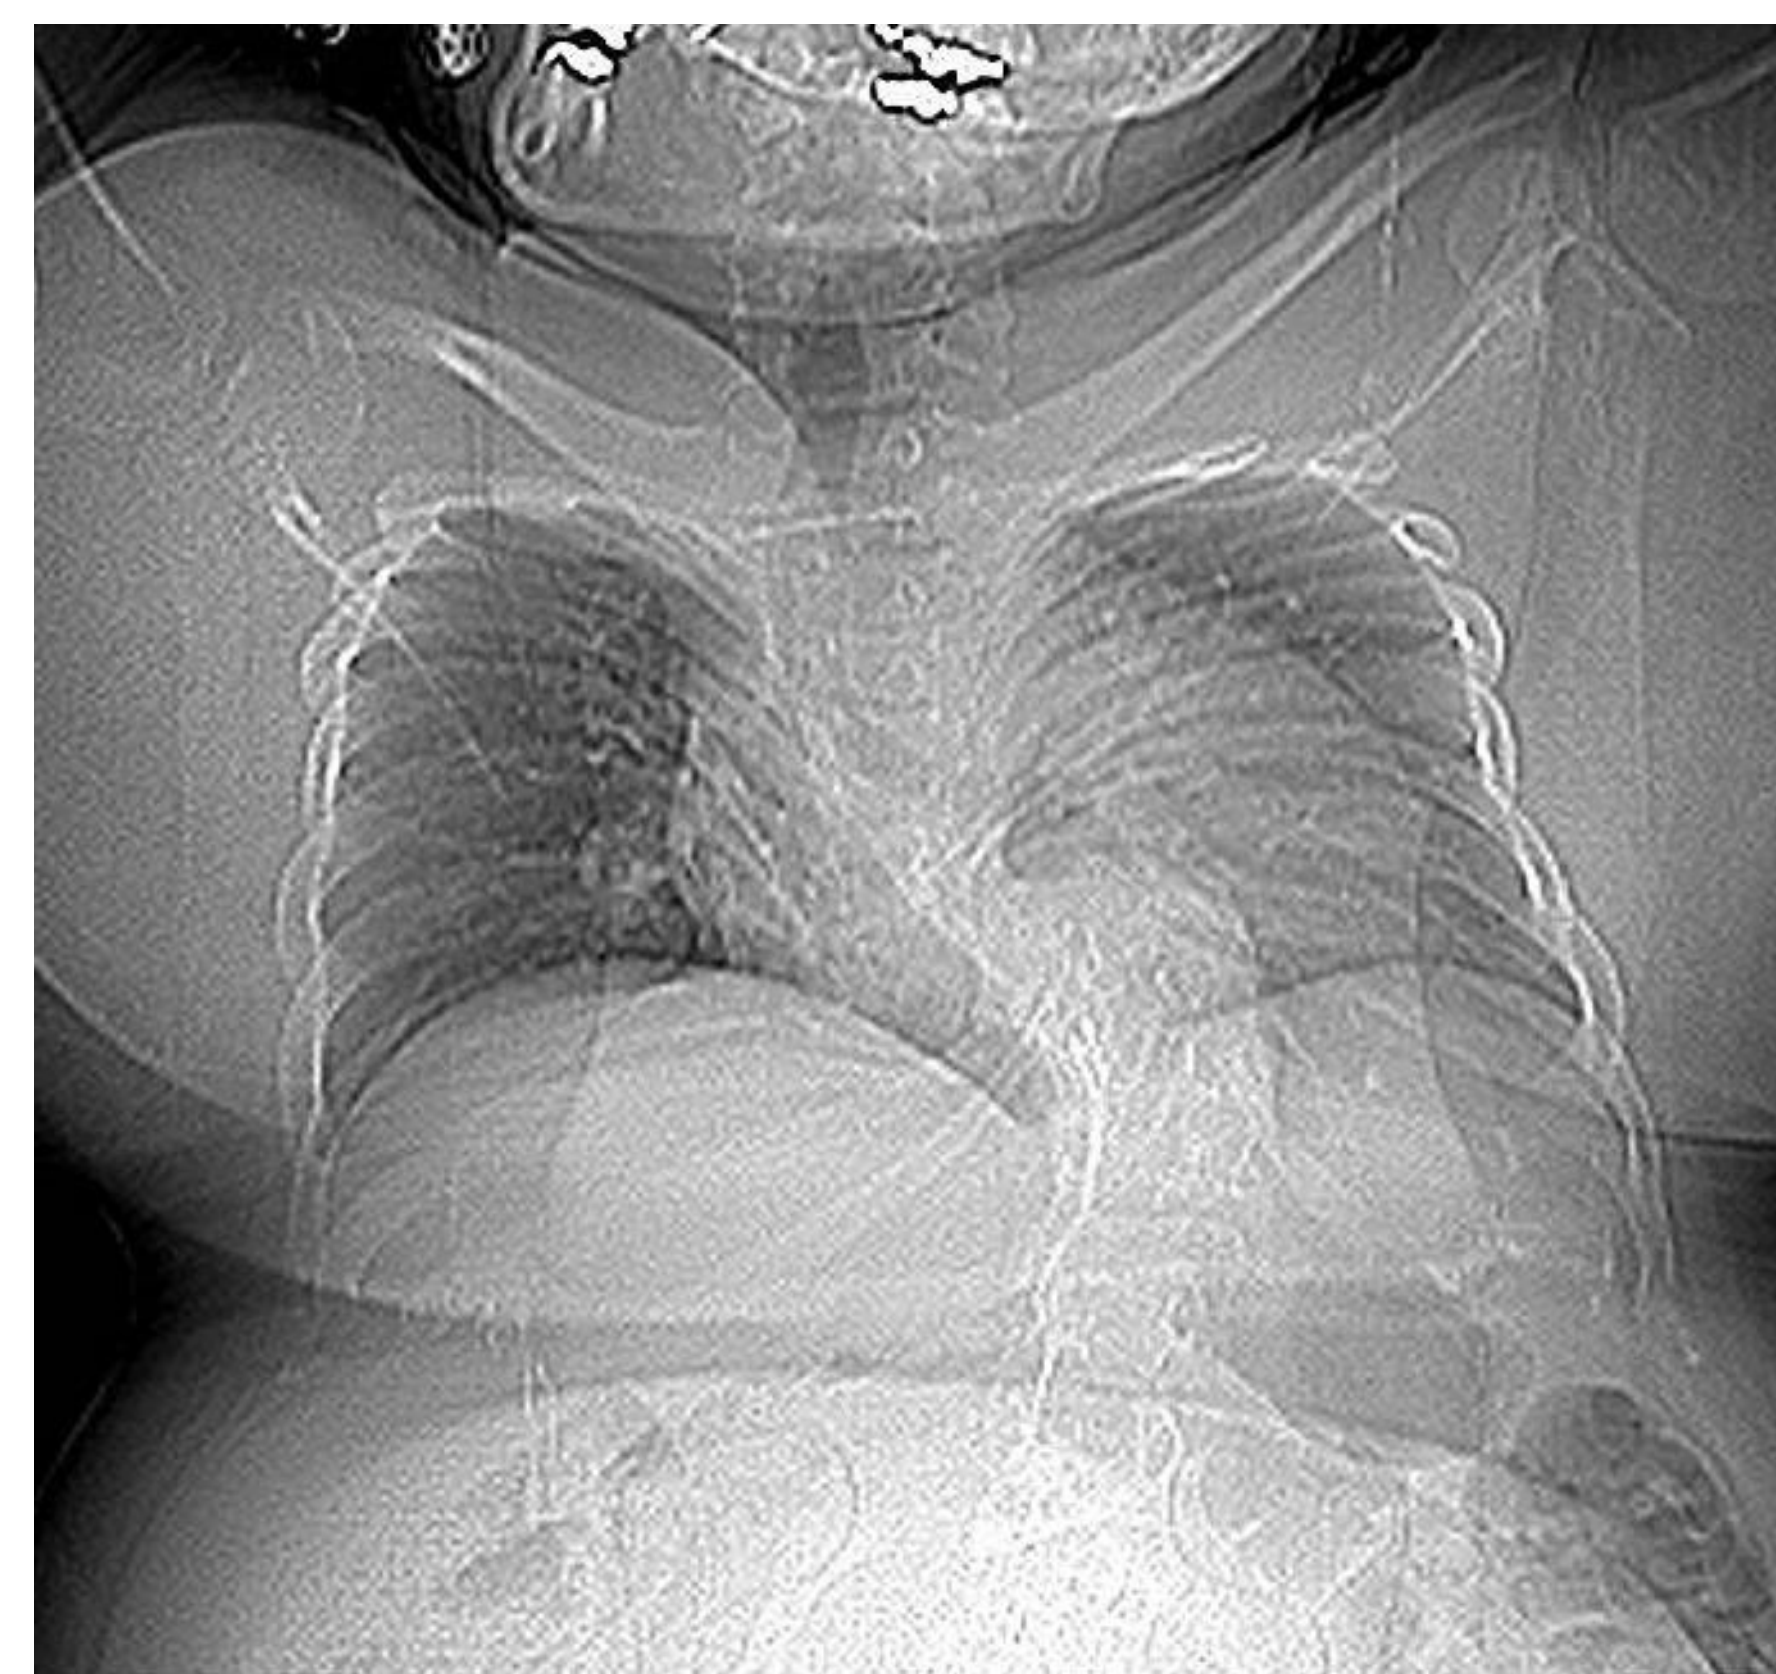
AP Chest x-ray with severe thoracic kyphoscoliosis.
